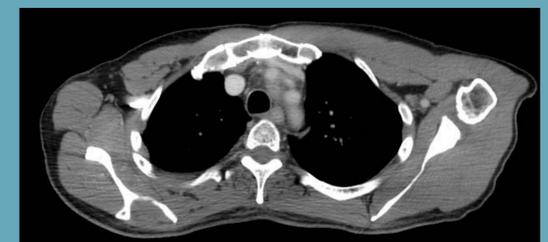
CT thorax at completion of treatment
